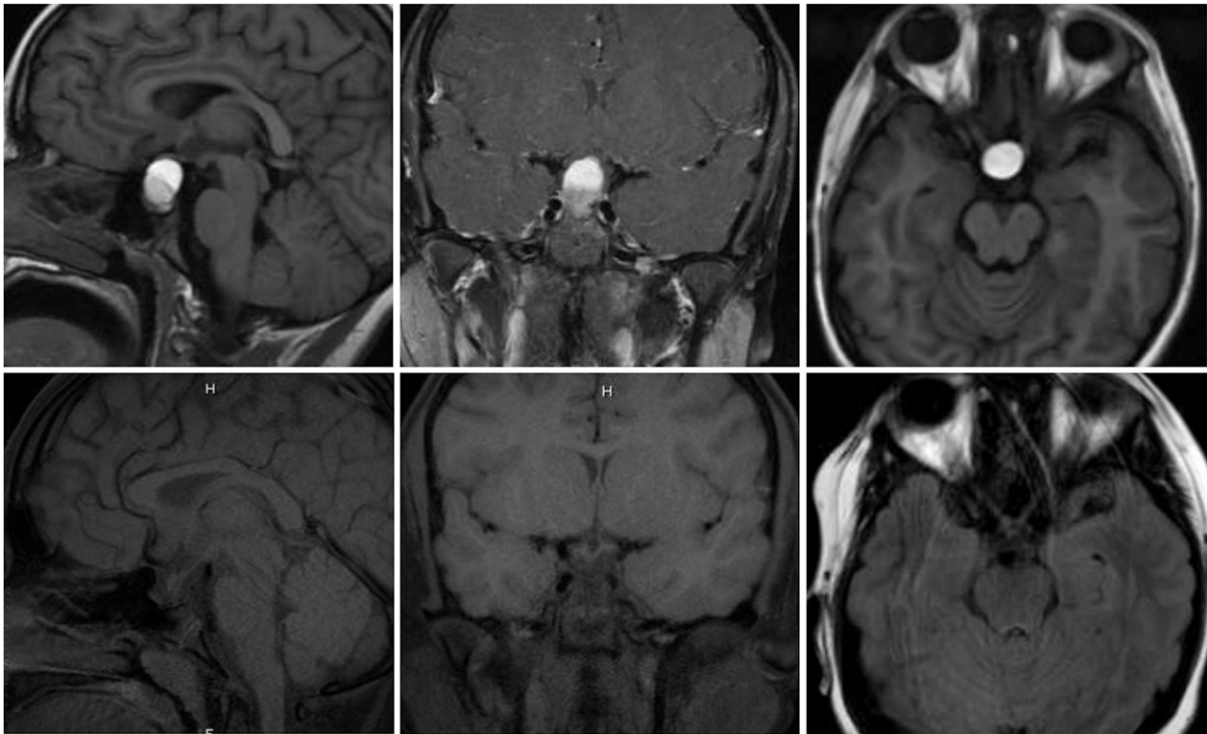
Comparison of preoperative T1-weighted magnetic resonance images (MRIs) (upper row) and MRI with dedicated images of the sella 18 months after resection via the transsphenoidal approach (bottom row). The hyperintense cystic lesion originally measured $1.4 \times 1.4 \times 2.1$ cm, with displacement of the optic chiasm superiorly. No residual cyst is evident in the postoperative images.
